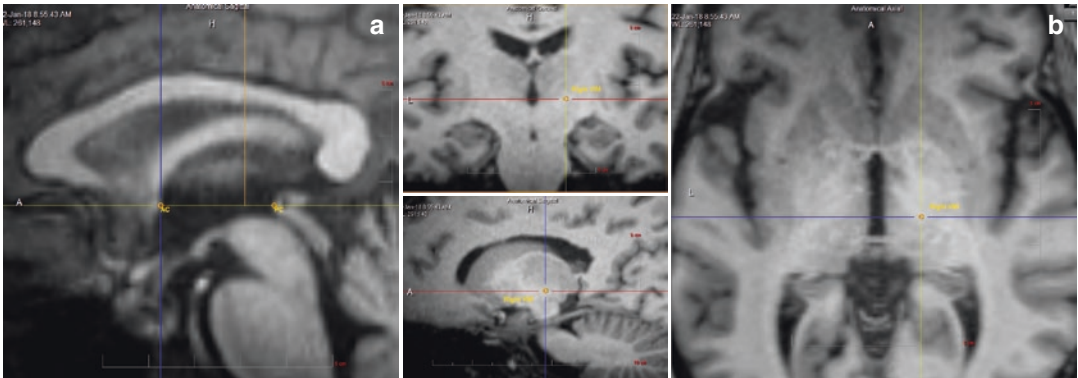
T1-weighted sagittal MRI demonstrating initial targeting of Vim thalamus at the level of the intercommissural plane ¼ the distance anterior to the posterior commissure (a) seen on axial, coronal, and sagittal T1-weighted MR images that better defines the location of the internal capsule (b)
